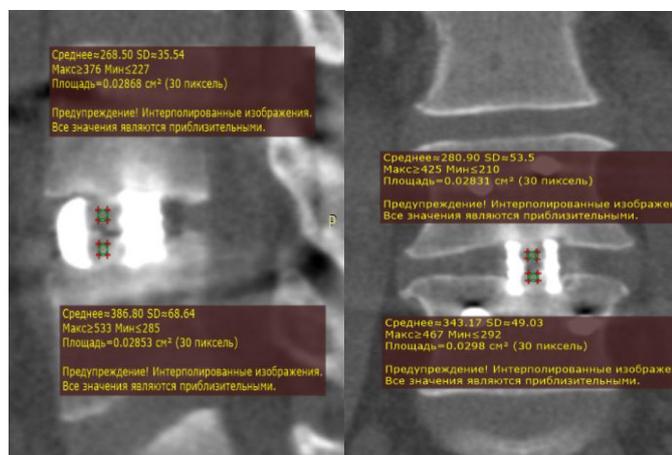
CT densitometry 4 months after surgical treatment in the trabecular cage area: measurement of X-ray density (HU) in standardized ROIs with an area of 30 pixels in the cranial and caudal parts of the interbody block
